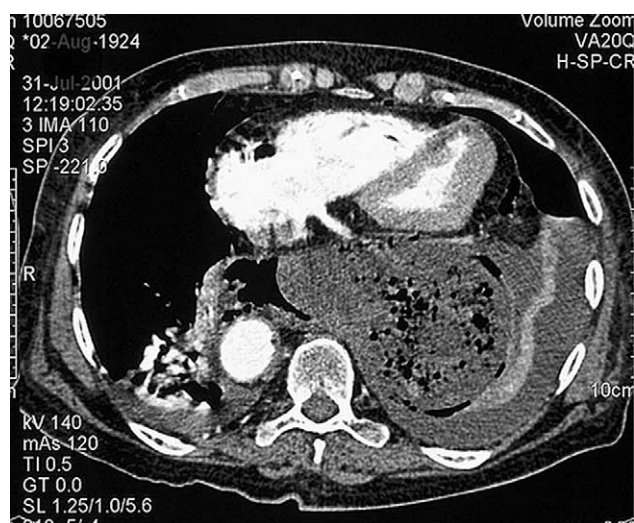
Computed tomographic scan of the thorax shows a seropneumothorax with extensive pulmonary atelectasis formation on the left side, multiple mediastinal air bubbles, a large paraesophageal hernia, and a right-sided descending aorta.
